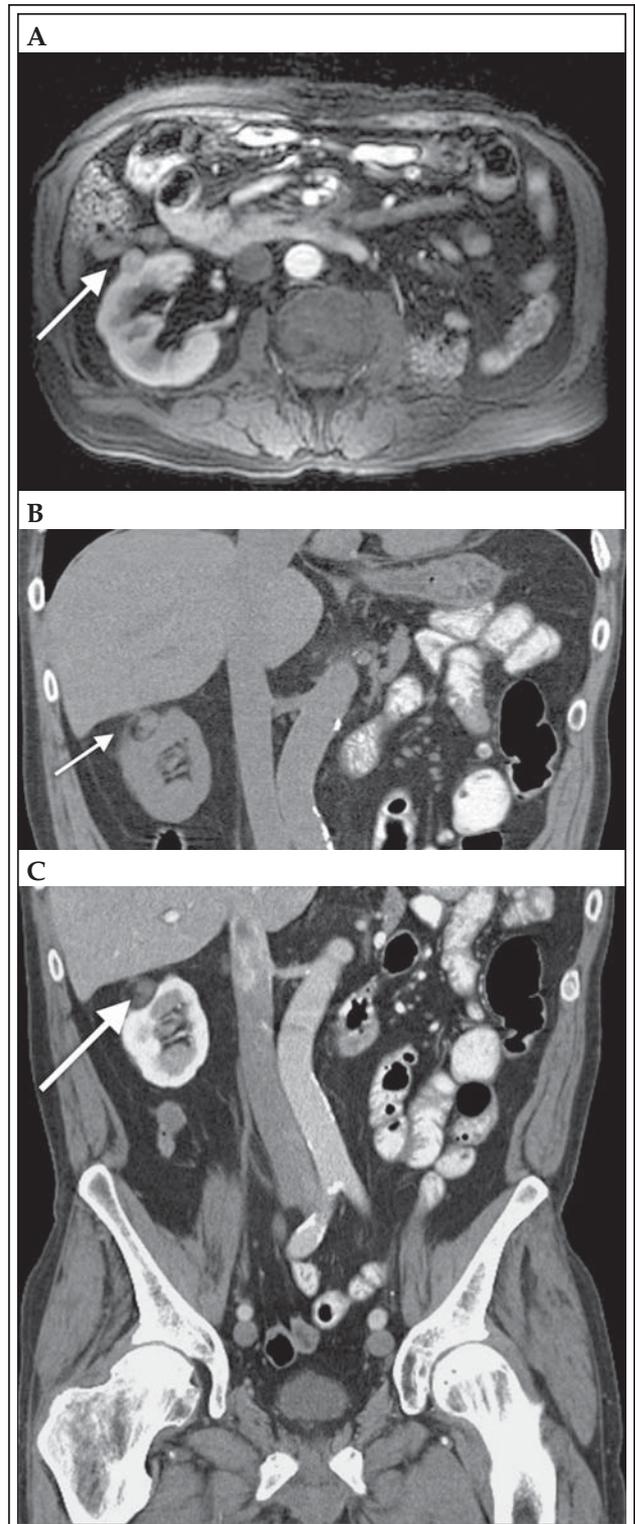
A) Ultrasound if tumor near renal vein (arrow). B) Immediate post ablation CT shows an enhancing rim (arrow). C) CT at 14 months shows interval enlargement. This was subsequently successfully treated with repeat percutaneous RFA.
